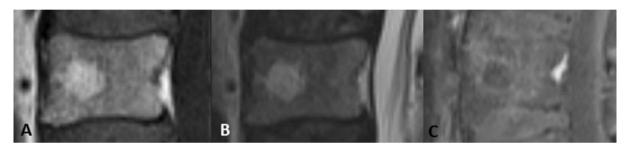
Athypical MRI features of vertebral haemangiomas of the dorsal column. Sagittal MRI shows low-signal intensity due to low adipocyte content in T1-w images (a - white arrowhead) and hyperintensity in the corresponding T2-w images (b – black arrowhead).
